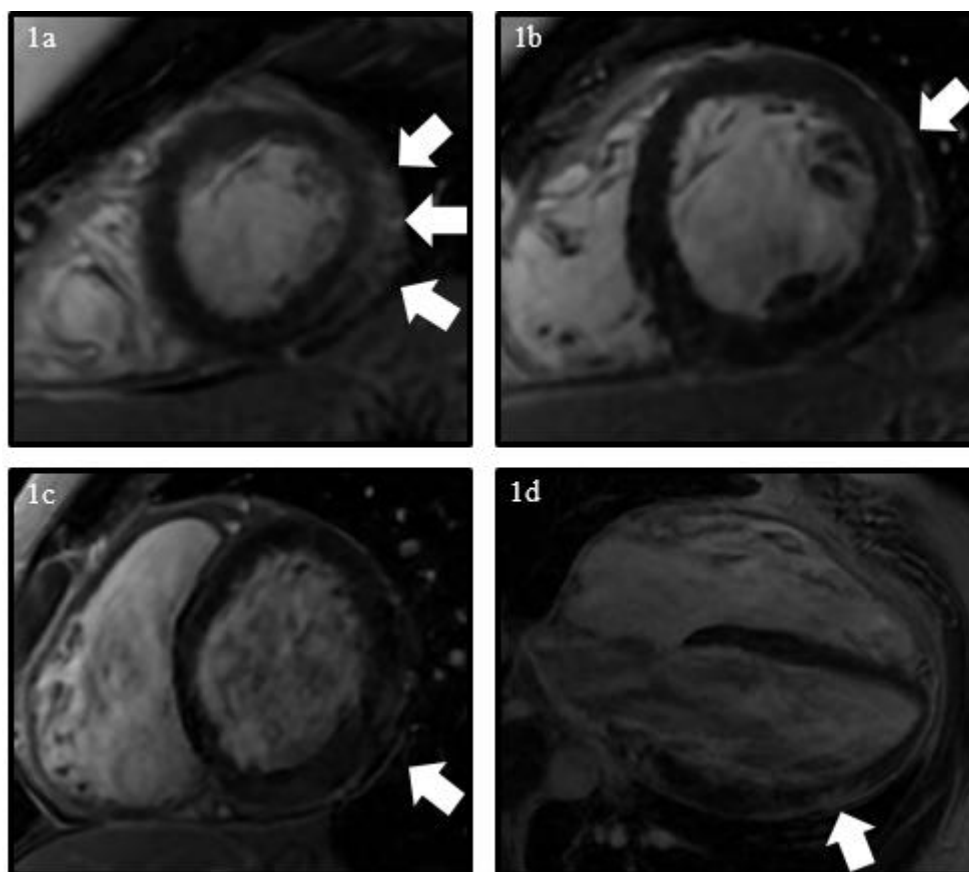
Cardiac magnetic resonance images of late gadolinium enhancement demonstrating subepicardial and mid-myocardial enhancement in the left ventricular mid-distal posterolateral/lateral wall on short-axis view (1a-1b), basal posterolateral walls on short-axis (1c), and mid-lateral wall in four-chamber (1d).
